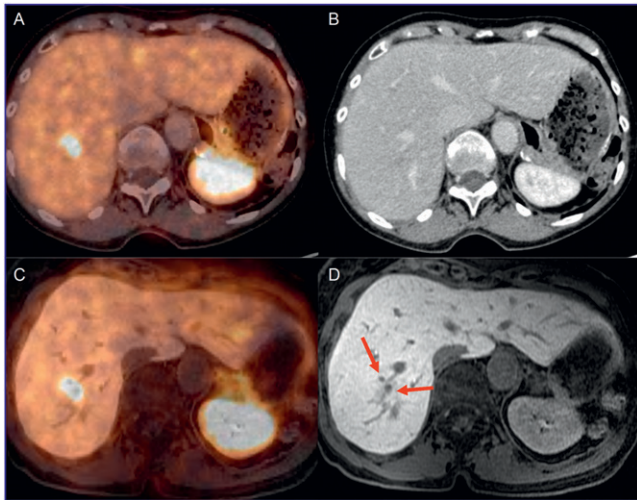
PET/MR fusion for detection of neuroendocrine tumor liver metastases. Top: ^{68}Ga -DOTATOC fused PET/CT (left) and contrast CT (right). Lesion is not seen on CT. Bottom: ^{68}Ga -DOTATOC fused PET/MR (left) and MR (right). Tumor is seen on MR.
